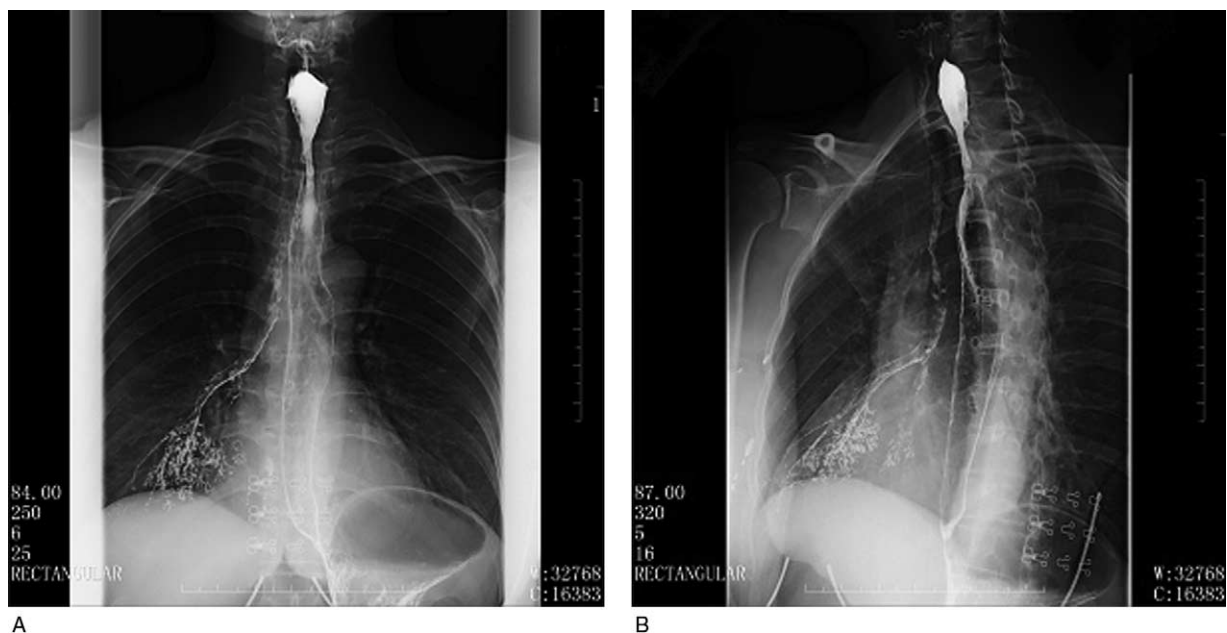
(A, B) A 47-year-old woman who had a barium swallow to screen for foreign body in esophagus. Chest radiographs demonstrated massive barium sulphate depositions in her trachea and inferior lobe of right lung.
